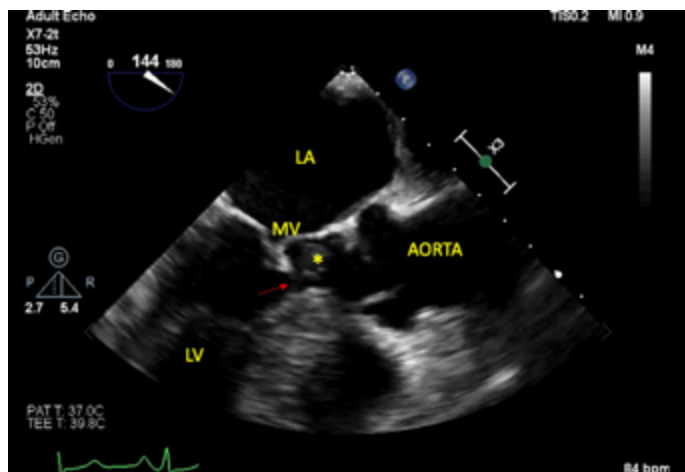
Accessory mitral valve tissue (*) extending to the left ventricular outflow tract with the presence of systolic anterior motion (red arrow) in transesophageal echocardiography midesophageal long axis view (LA, Left Atrium; MV, Mitral Valve).
